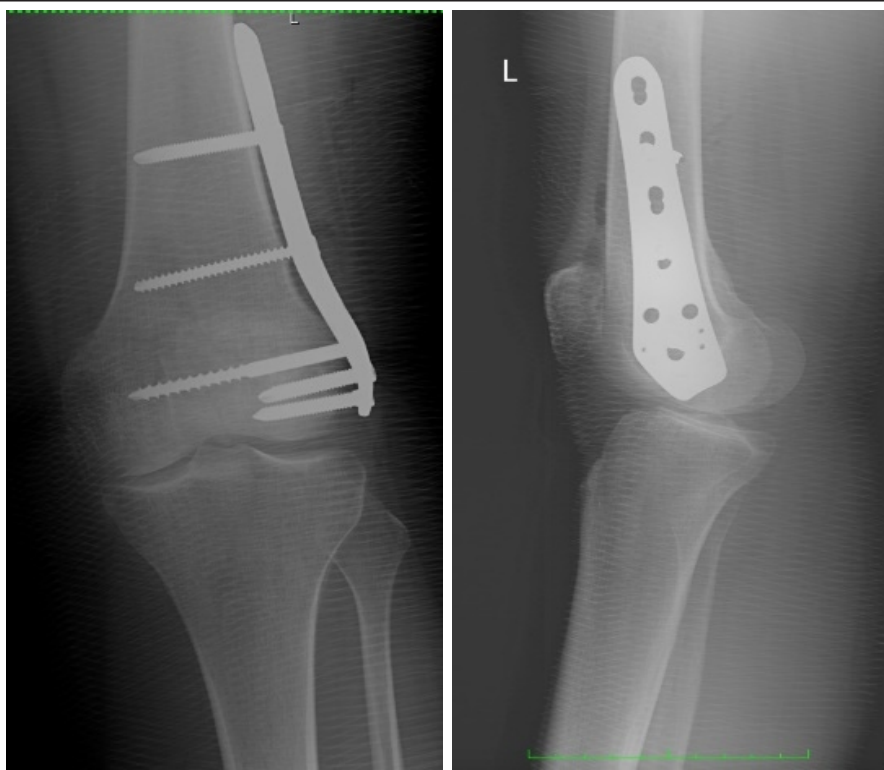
(a) AP and (b) lateral radiographs of the left distal femur after extensive curettage. The osteosynthesis plate is placed at the level of the lateral condyle.
